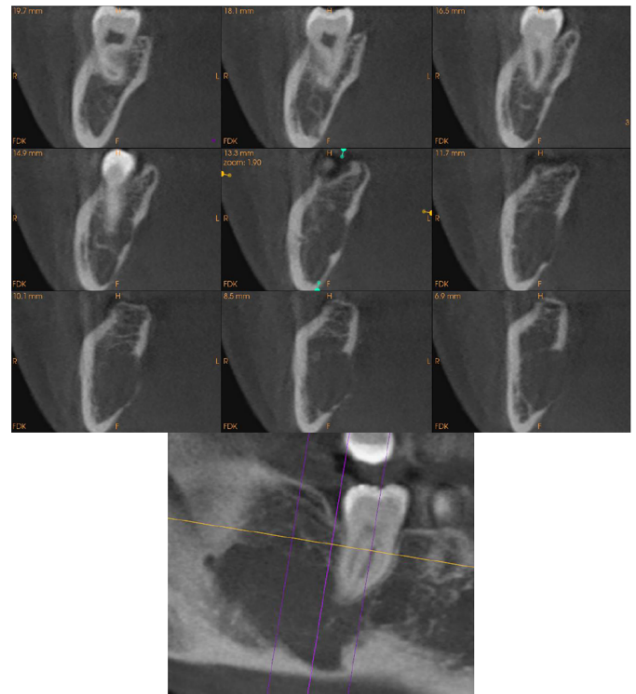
Axial views of the CBCT in Fig. 6. Note the expansion of the cyst and thinning of the lingual cortical plate
